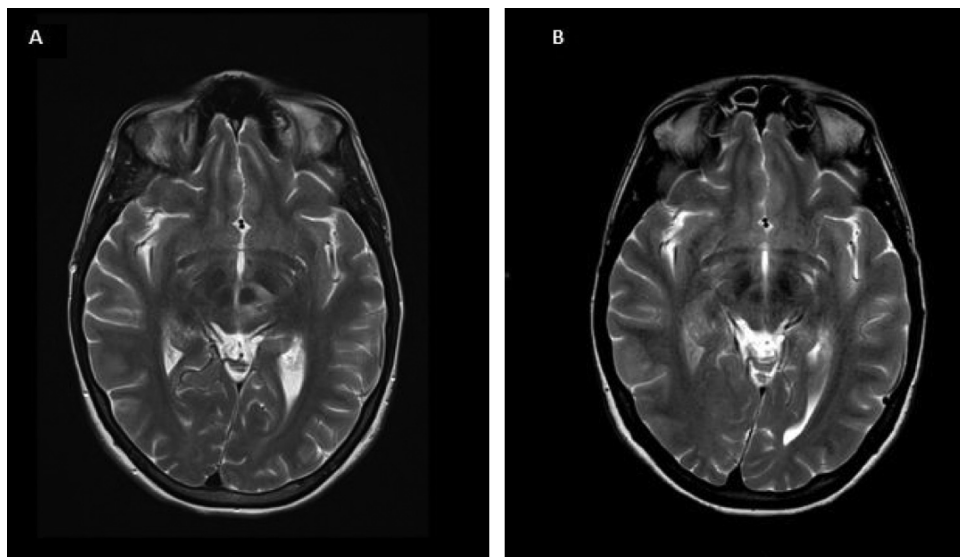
Patient 16: A. Preoperative axial T2-weighted brain MRI showing left red nucleus smaller than the contralateral side and surrounded with edema. B. Postoperative axial T2-weighted brain MRI showing disappearance of the edema but the presence of hemosiderin around the nucleus and in the substantia nigra.
